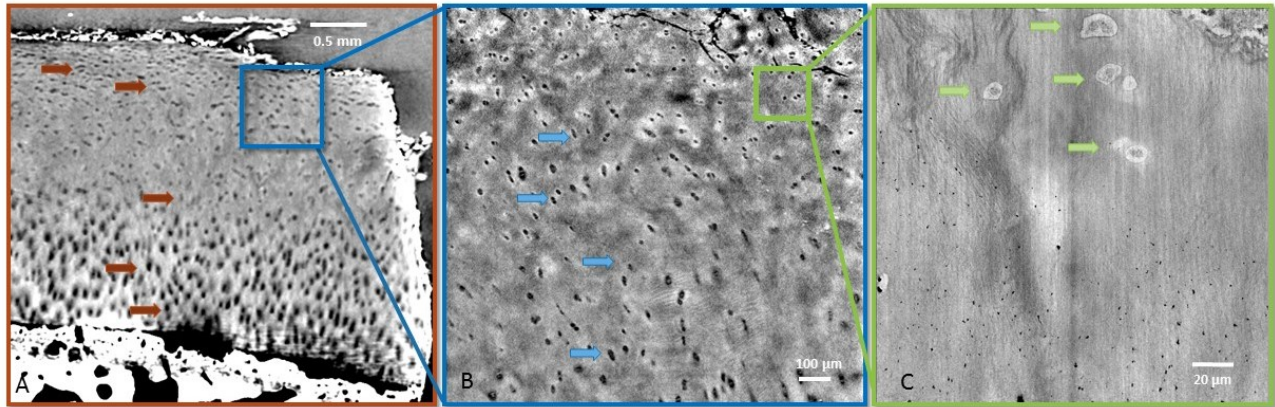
Multiscale images of the cartilage tissue acquired with different pixel sizes. Arrow indicating chondrocytes A) 6 μm pixel size and 60 keV X-rays, an overview of the cartilage with its different regions; B) 0.7 μm pixel size and filtered polychromatic X-ray beam, an image of a sub-region in the cartilage, a detailed view of the chondrocyte distribution are given; C) 0.1 μm pixel size, and 17 keV, details of the structure of the cells are visible.
